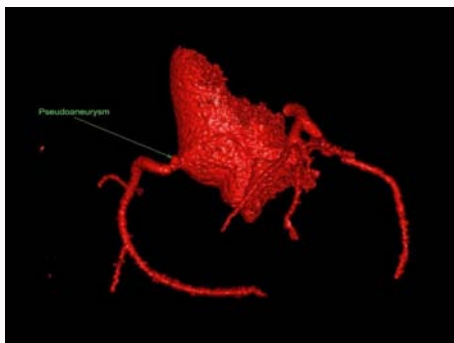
Surface rendered Cardiac CT day 1 post-surgery demonstrating a right coronary artery pseudoaneurysm. Left main stem is widely patent.
